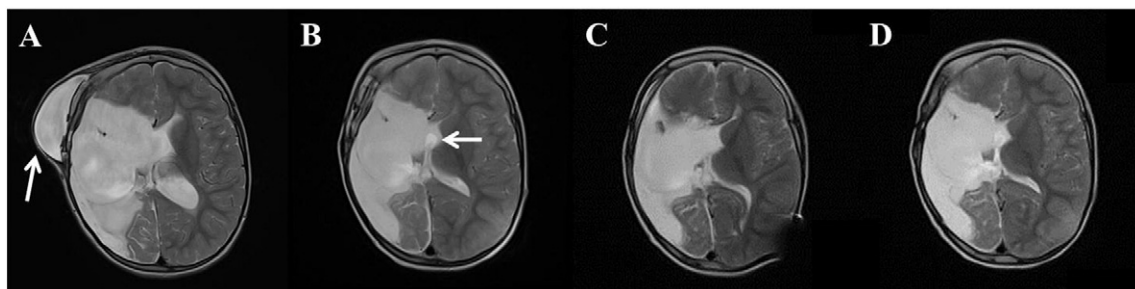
Axial T2 MRI images obtained just before the shunt placement (A), about 10 days after the shunt surgery (B), about 5 months after the surgery and immediately before the shunt valve re-adjustment (C), and about 3 months after the valve re-programming (D) show overall stable ventricular size and configuration, except an initial expected postoperative decrease in the size of the ventricles and pseudomeningocele. The white arrow in (A) points to a pseudomeningocele at the prior operative site, and the white arrow in (B) points to the approximate location the ventricular catheter tip (The catheter tip is not shown in this particular image slice).
